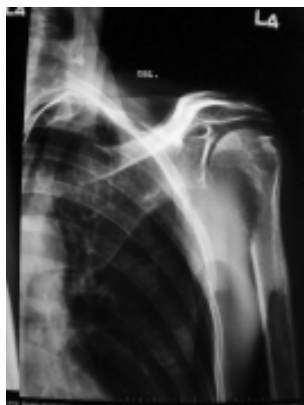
X-ray of left shoulder joint oblique view, showing metastasis
